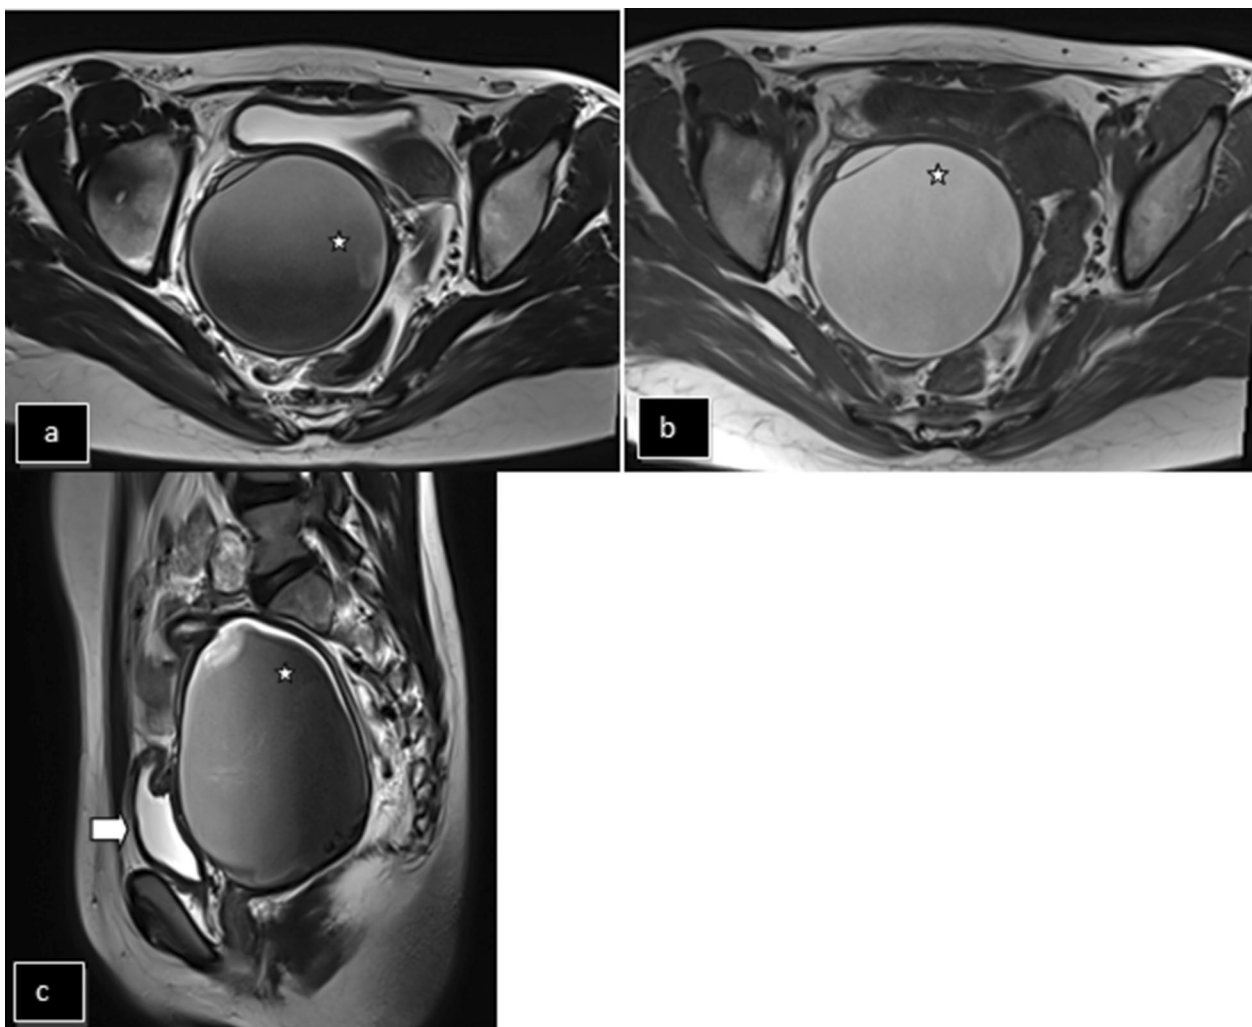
a–c MRI axial T2W axial, T1W axial and T2W sagittal images. The right hemivagina is distended by T1 hyperintense (star in b), T2 hypointense (stars in a and c) collection measuring $7.4 \times 7.4 \times 9.5$ cm and low-lying debris displacing the left hemivagina, rectum to the left and compression of the urinary bladder anteriorly (arrow in c)—likely obstructed right hemivagina with subacute blood secondary to longitudinal vaginal septum
